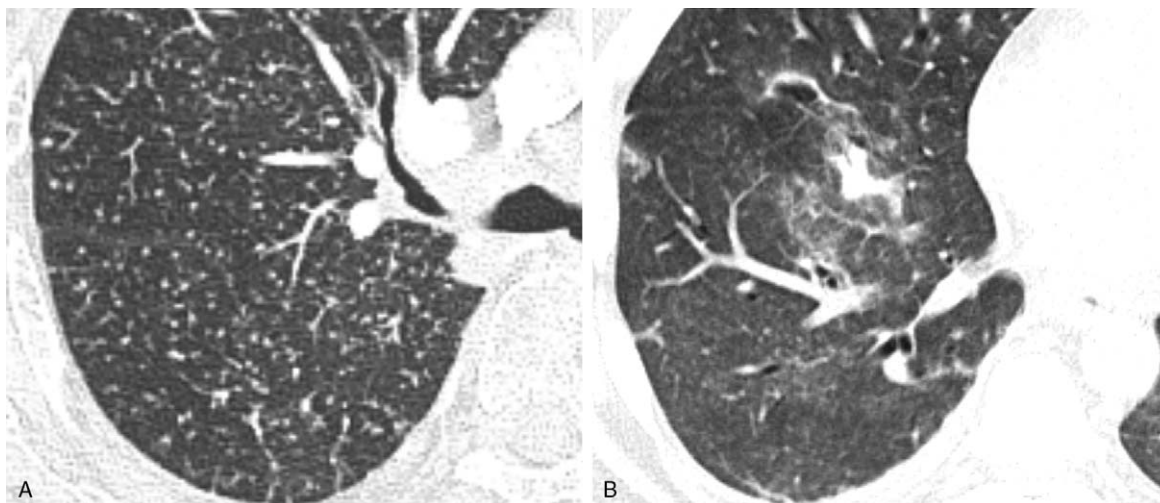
Example of CT interpretation of miliary nodules. (a) Miliary nodule with well-defined nodules measuring 2–4 mm and showing random distribution on axial high-resolution CT. (b) Miliary nodule with ill-defined miliary nodules measuring less than 2 mm showing coarse and granular appearance on axial high-resolution CT.
